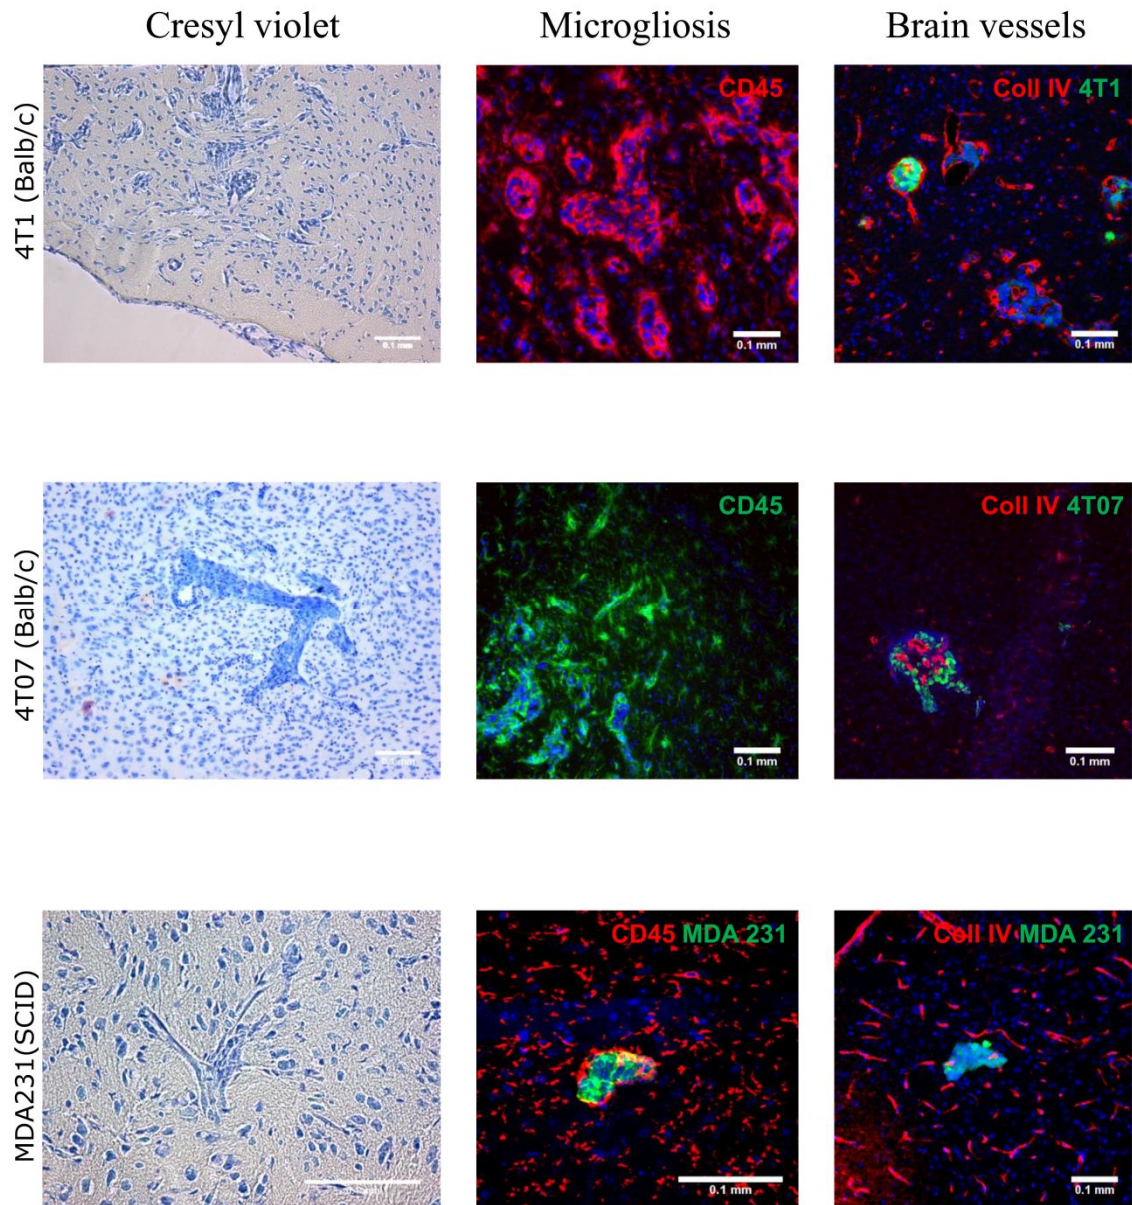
Intracardiac injection of 4T1, 4T07 or MDA -MB-231 cells using ultrasound guidance consistently give rise to parenchymal brain metastases
